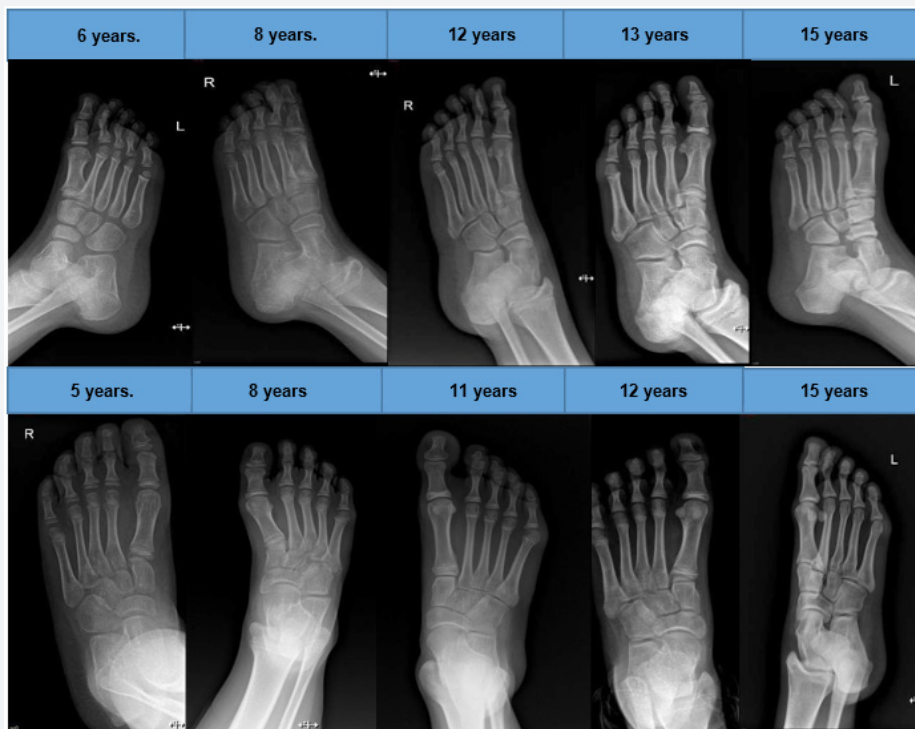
The development and fusion of the ossification nucleus is seen more clearly in girls between 9-14 years old and in boys: 11-16 years old. Sequence of standing x-rays, oblique projection. Above. Male development. Below. female development.
